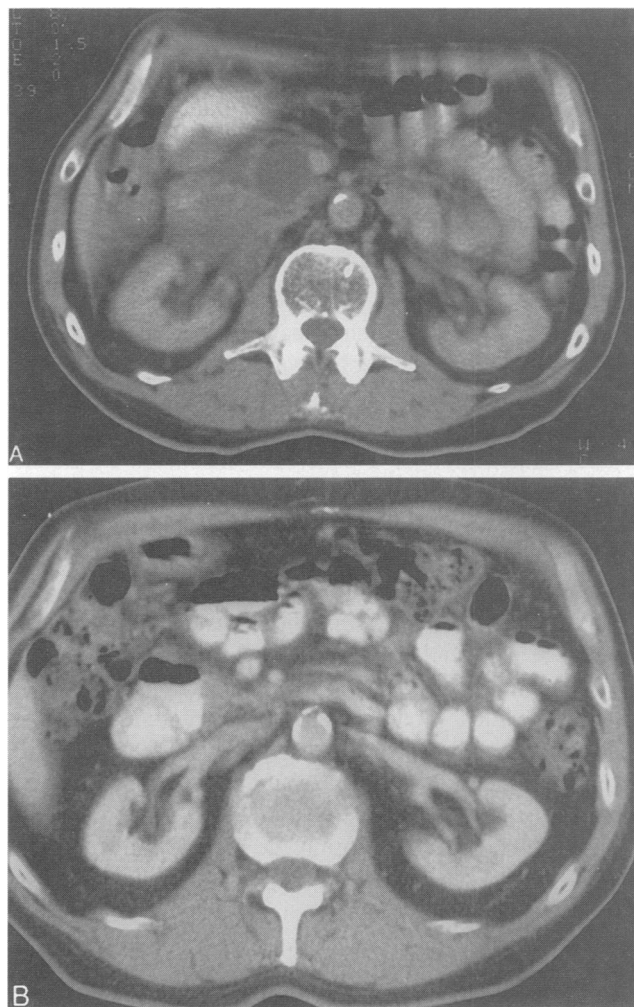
CT of patient (A) before and (B) 7 years after enucleation.
